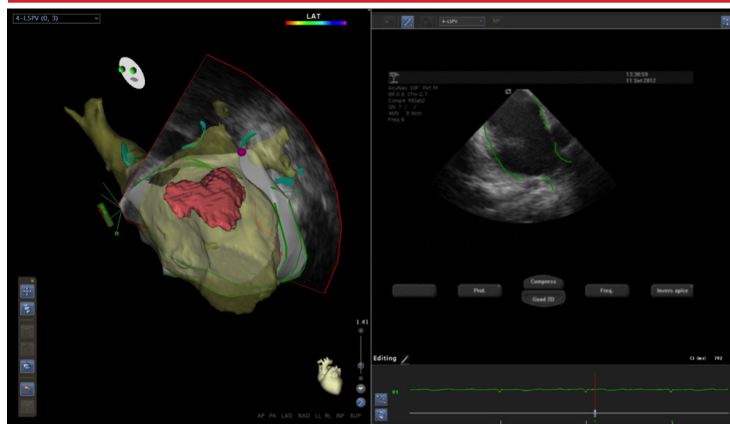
Screen shot of the CARTO system. On the left, intracardiac echocardiography (ICE) 2D image of the left atrium (LA), left superior and left inferior pulmonary veins. The green lines represent the endocardial borders. On the right, co-registration of the LA ICE 3D anatomical shell and preoperative cardiac CT scan
